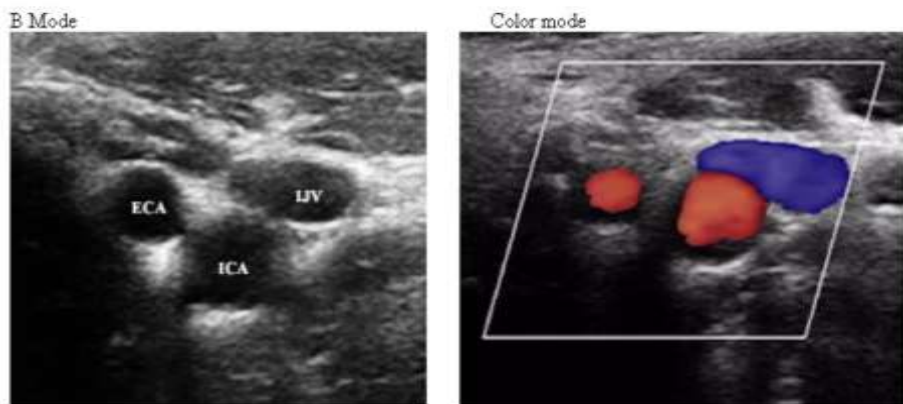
Internal carotid artery, external carotid artery, internal jugular vein, cross-section B-mode (left), colour-coded Doppler mode (right).
